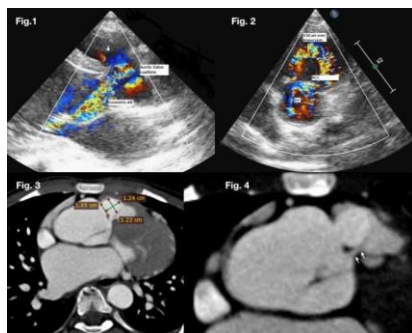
Parasternal long-axis view shows eccentric severe aortic regurgitation jet with dilated aortic root.
